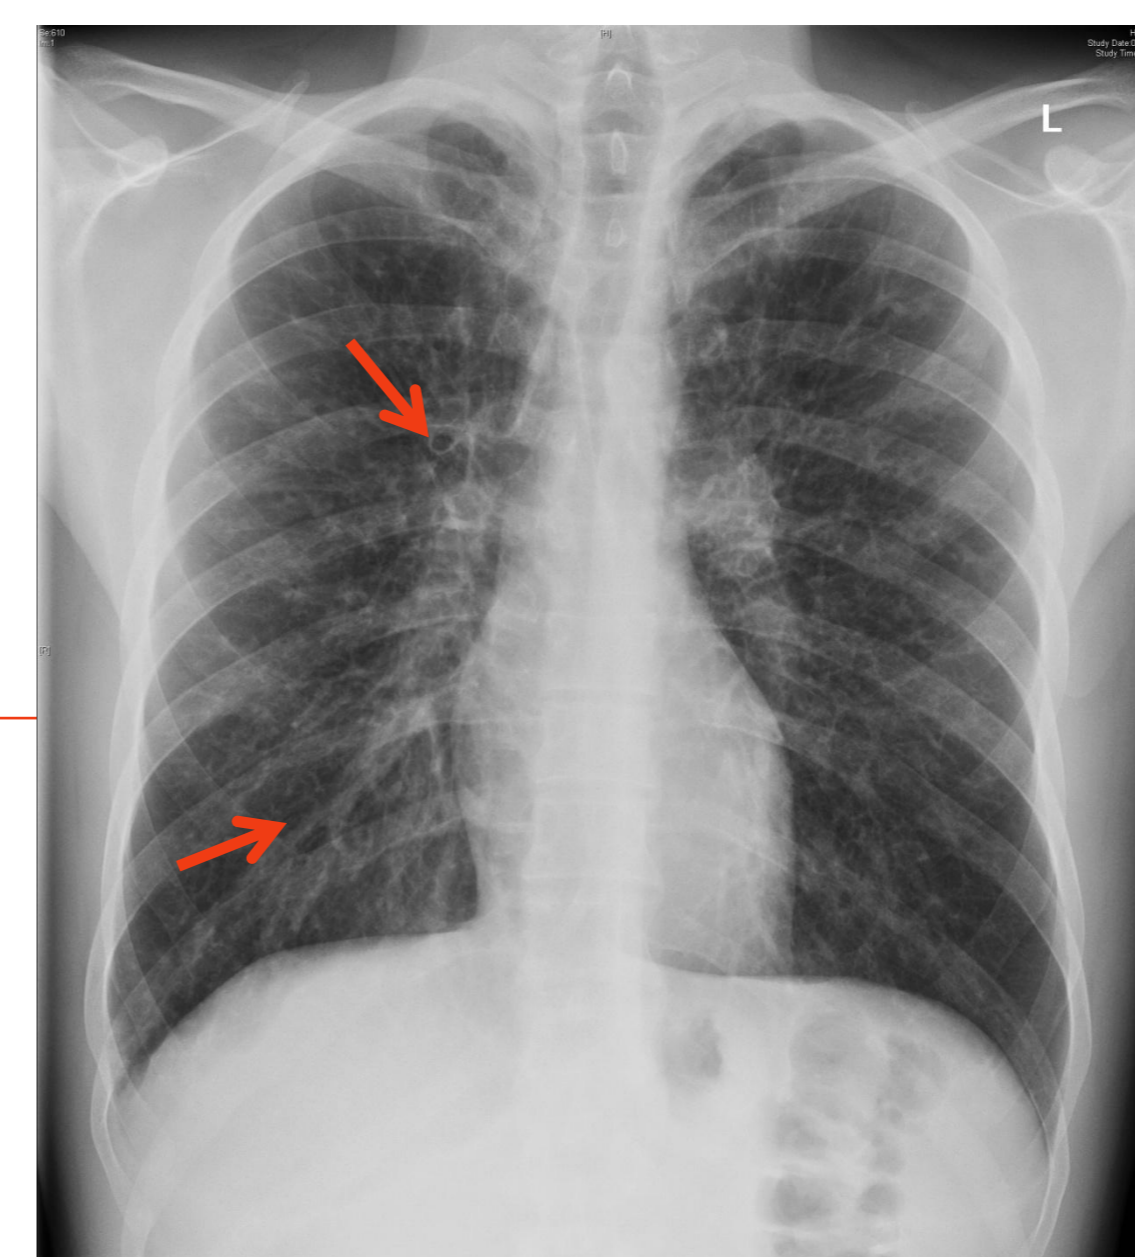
ring structures, streaky and nodular opacities on chest radiograph
